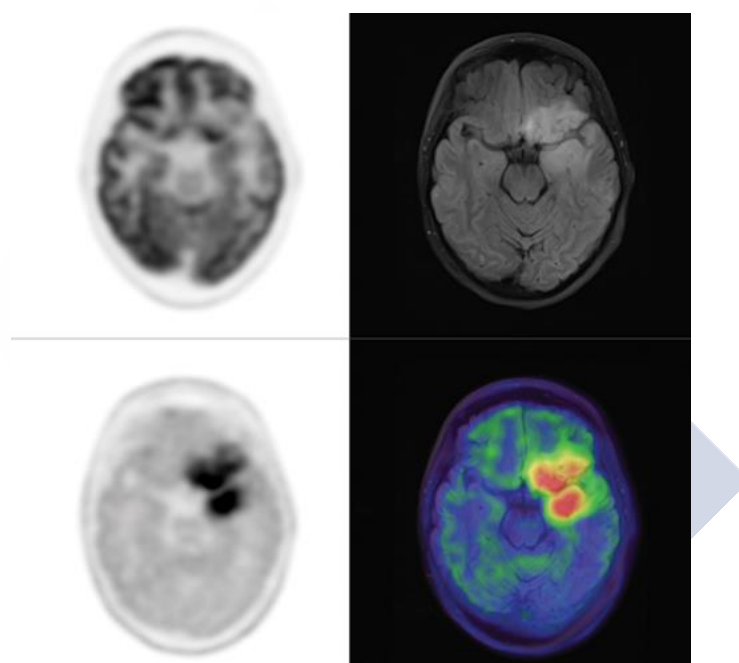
A glioma imaged with FDG (top left) and FDOPA PET (bottom left). We can observe the higher contrast of the amino acid imaging when compared with FDG. We also can see the much better correspondence between FDOPA and MRI image (top right). Bottom right shows FDOPA/MRI co-registration. Image is reproduced from Intech Open Access library (DOI: 10.5772/62823)
